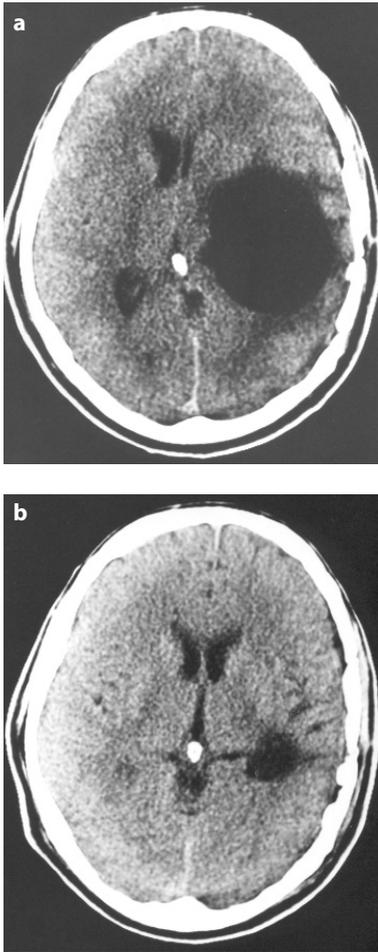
a, b. Axial CT scans. a Blockage of temporal horn by endymenitis. a Postoperative follow-up after endoscopy
